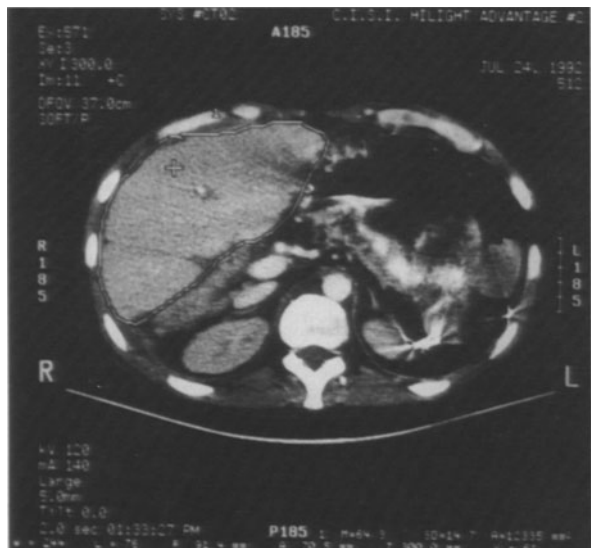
Second liver xenograft (baboon-to-human) recipient. Abdominal computed tomography (CT) on postoperative day 14. The liver volume has increased to 1741 cm³, from an initial value of 450 cm³. (From [96])
